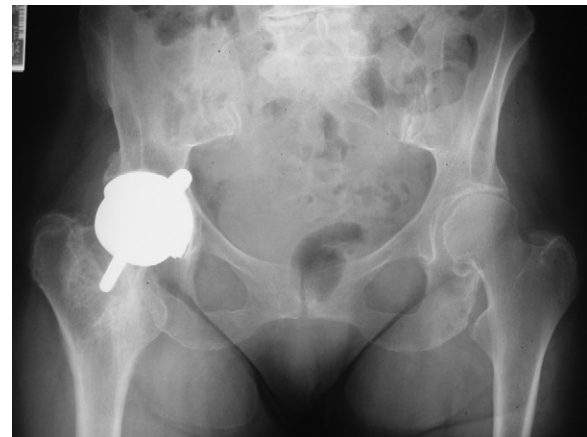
Patient 1 radiograph AP pelvis (United).
